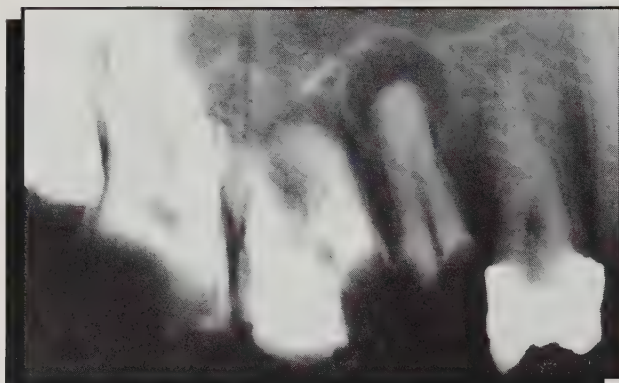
The density and contrast of the mesial half of the image depicted in Fig. 1 was enhanced to better demonstrate the periapical area of tooth 24.
